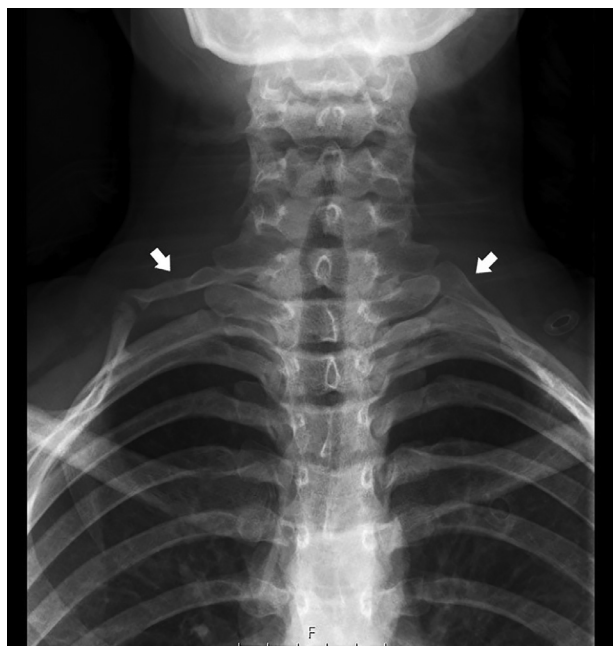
Neck x-ray showing bilateral cervical ribs, emerging from the C7 vertebra (white arrows).
